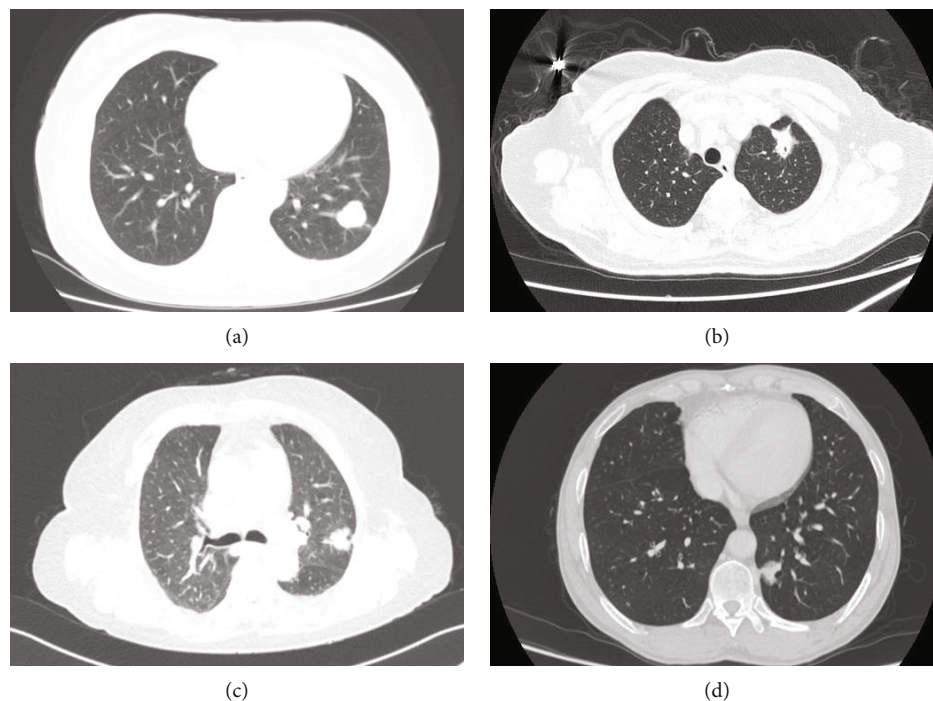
CT imaging of lung adenocarcinomas with MLCs. CT scans showed a solid mass in almost all patients (a–c). A well-defined solid mass in case 1 (a). A spiculated solid mass in case 3 (b). A lobular solid mass in case 16 (c). A mass composed of the central solid component and peripheral ground-glass opacity in case 12 (d).
